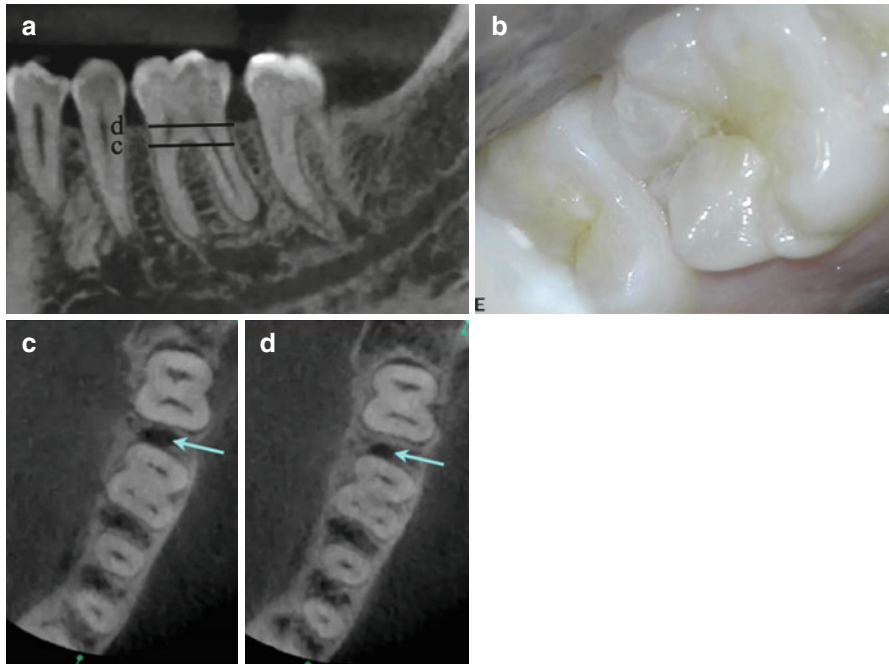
Patient presented for evaluation and treatment of tooth number 19. The chief complaint was pain on biting and sensitivity to hot drinks. Clinical findings: no response to cold and positive response to bite stress testing. A diagnosis of a necrotic pulp and symptomatic apical periodontitis was established. The presumed etiology was extension of a distal marginal ridge crack. (a) Sagittal view of tooth number 19 showing a distal root periapical radiolucency. The *lines* on the sagittal view correspond to the axial section views (c) and (d). (b) Clinical image (occlusal view) demonstrating the distal marginal ridge crack. Axial views (c) and (d) demonstrate the distal bone loss associated with the fracture (*blue arrows*) and unfavorable prognosis
